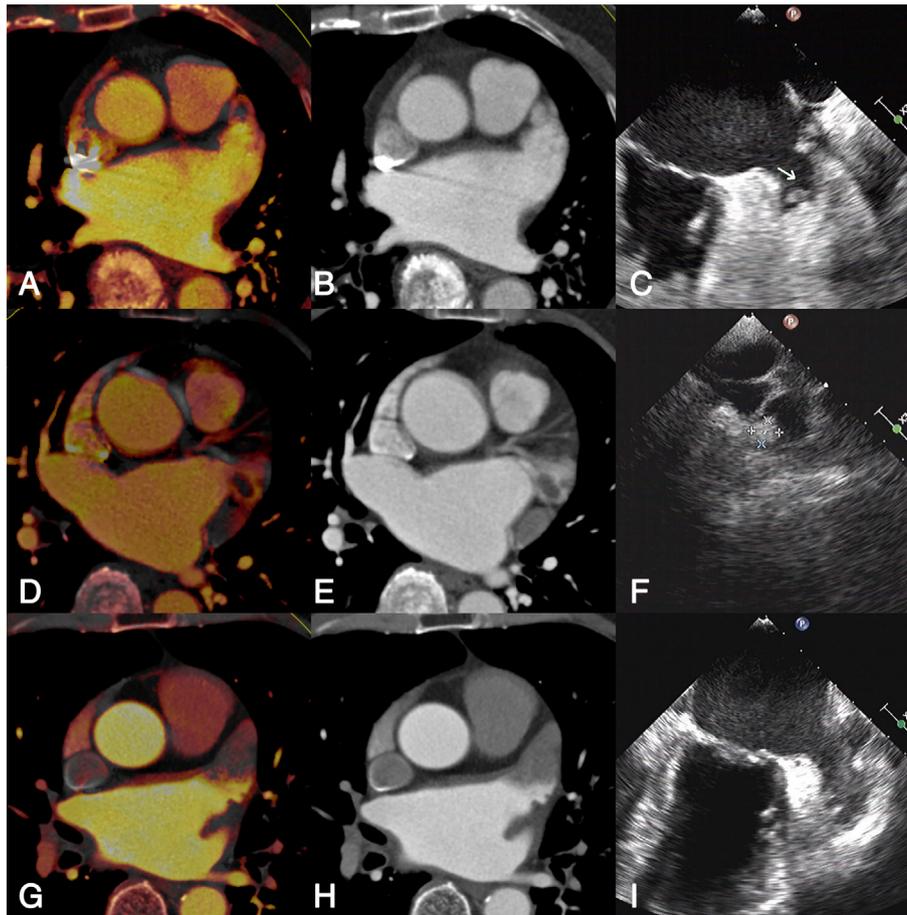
Panels A–C: Representative images from an 80-year-old male patient with AF. Iodine map (panel A) shows a filling defect in the LAA (iodine concentration = -5.8 mg/ml) (true positive finding). Conventional enhancement CT (panel B) shows no definite filling defect in the LAA (LAA/AA HU ratio = 0.332) (false negative finding). TEE image (panel C) shows a thrombus (arrow) with SEC. Panels D–F: Representative images from a 69-year-old female patient with AF. Iodine map (panel D) shows a filling defect in the LAA (iodine concentration = -2.1 mg/ml) (true positive finding). Conventional enhancement CT (panel E) shows a filling defect in the LAA (LAA/AA HU ratio = 0.096) (true positive finding). TEE image (panel F) shows a thrombus. Panels G–I: Representative images from a 62-year-old female patient with AF. Iodine map (panel G) shows partial filling defect in the LAA (iodine concentration = 1.9 mg/ml) (true negative finding). Conventional enhancement CT (panel H) shows a filling defect in the LAA (LAA/AA HU ratio = 0.232) (false positive finding). TEE image (panel I) shows severe SEC without a thrombus. For quantitative assessment, an iodine concentration of -1.3 mg/ml or less was considered positive for thrombi. An LAA/AA HU ratio of 0.304 or less was considered positive for thrombi. Conventional enhancement CT images (combined 70-kV and 150-kV images) which approximate the image quality of a conventional 120-kV and iodine maps were automatically generated from DECT scans.
